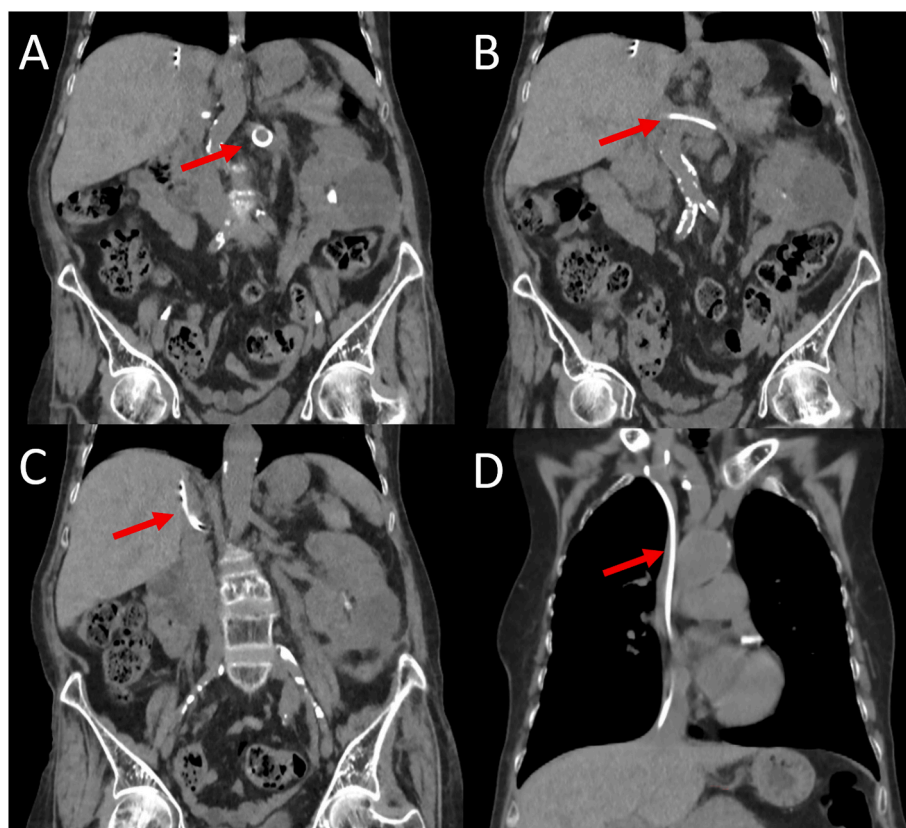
A computed tomography (CT) scan of the abdominopelvic and chest revealed a foreign body passing through the left renal vein to the superior vena cava and right brachiocephalic vein, at the junction of the jugular vein; red arrows indicate the path of the migrated ureteral stent.
